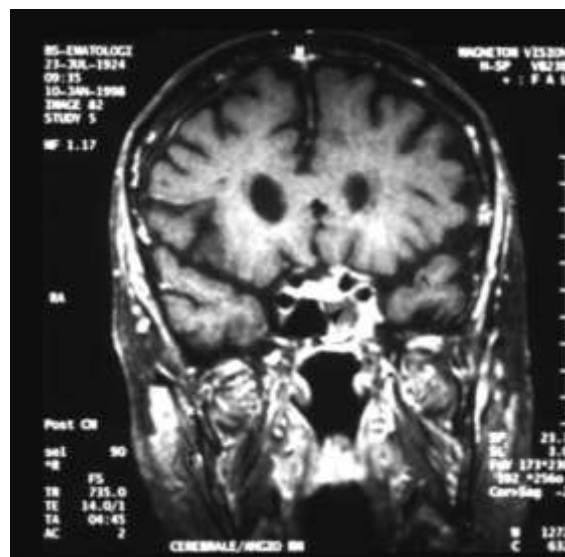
Spin-echo T₁ MRI on a coronal plane showing an opacified, hypointense left sphenoid sinus with a small component of intensity similar to that of the muscle (arrowhead).
